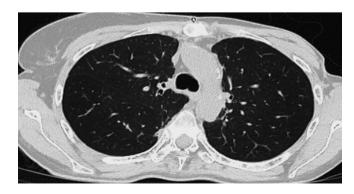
Chest CT scan 14 days after initiation of therapy: regression of infiltrative changes in the right lung; decreased inflammatory involvement in segments S2, S4–5, S6, and S8 on the right; reduced pleural effusion in the left pleural cavity
